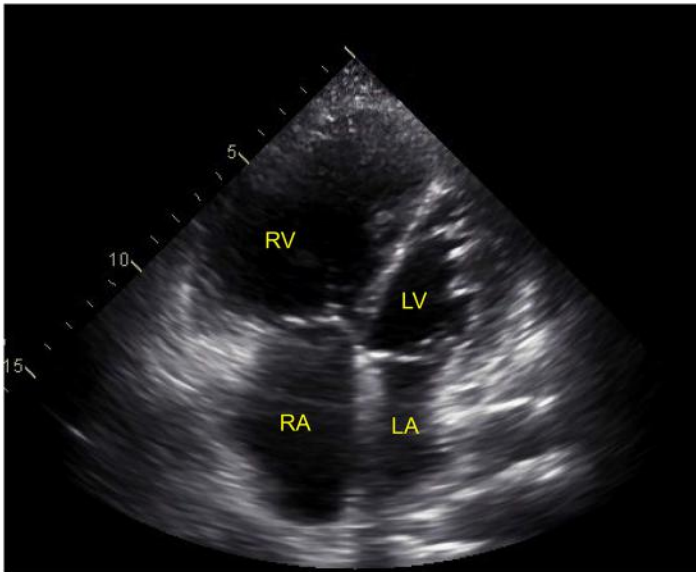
Apical 4-chamber view from a TTE demonstrating severe RV dilation in a patient with severe PAH and RVF. LA, left atrium; RA, left atrium.
